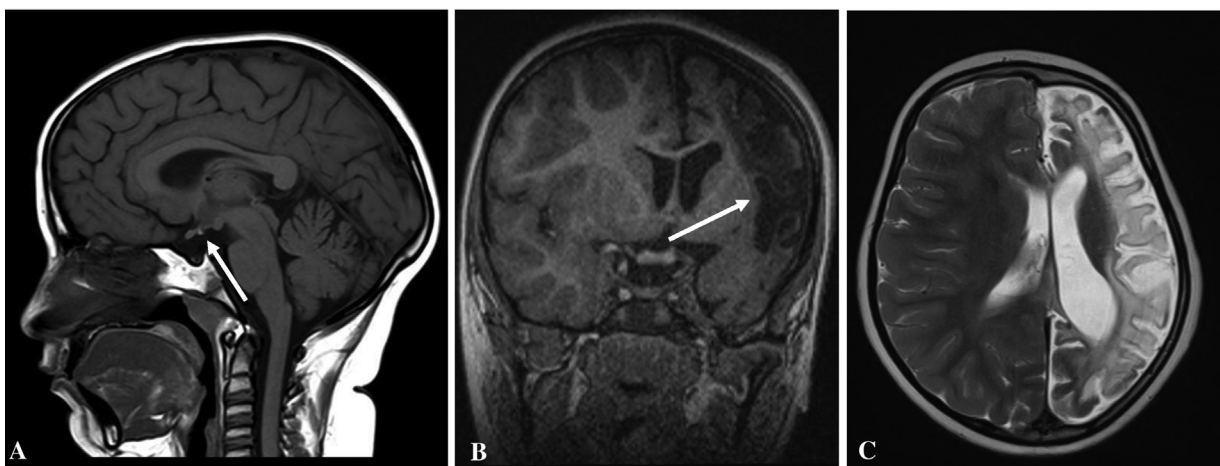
A 5-year-old female child patient presented with right hemiparesis and developmental delay. On examination, she had height of less than 3 standard deviation (SD) of her age. Growth hormone, luteinizing hormone (LH), and follicle-stimulating hormone (FSH) deficiency was seen on hormone analysis. Sagittal, coronal T1-weighted (T1W), and axial T2W magnetic resonance imaging (MRI) images demonstrating ectopic T1W bright spot, located at the median eminence with gliosis and hemiatrophy of left hemisphere, ex vacuo dilatation of left lateral ventricle and compensatory bone hypertrophy seen in Dyke-Davidoff-Masson syndrome.
